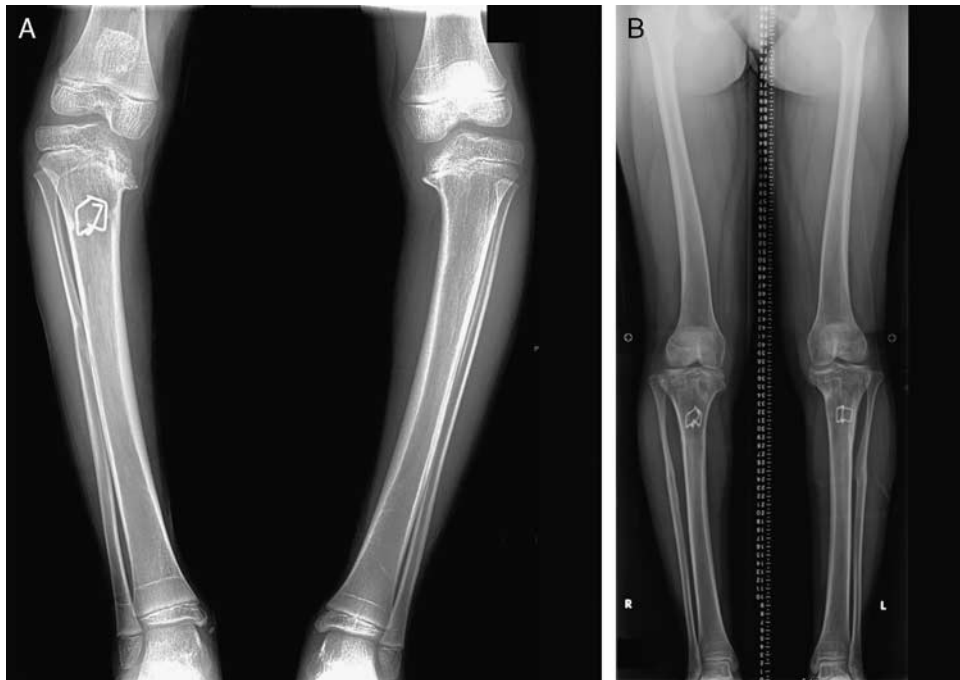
Case 6 patient with bilateral infantile tibia vara preoperative radiographs (A) and bilateral correction of mechanical axes measured within 1 degree of 0 (B). Limb-length discrepancy was <1 cm.
